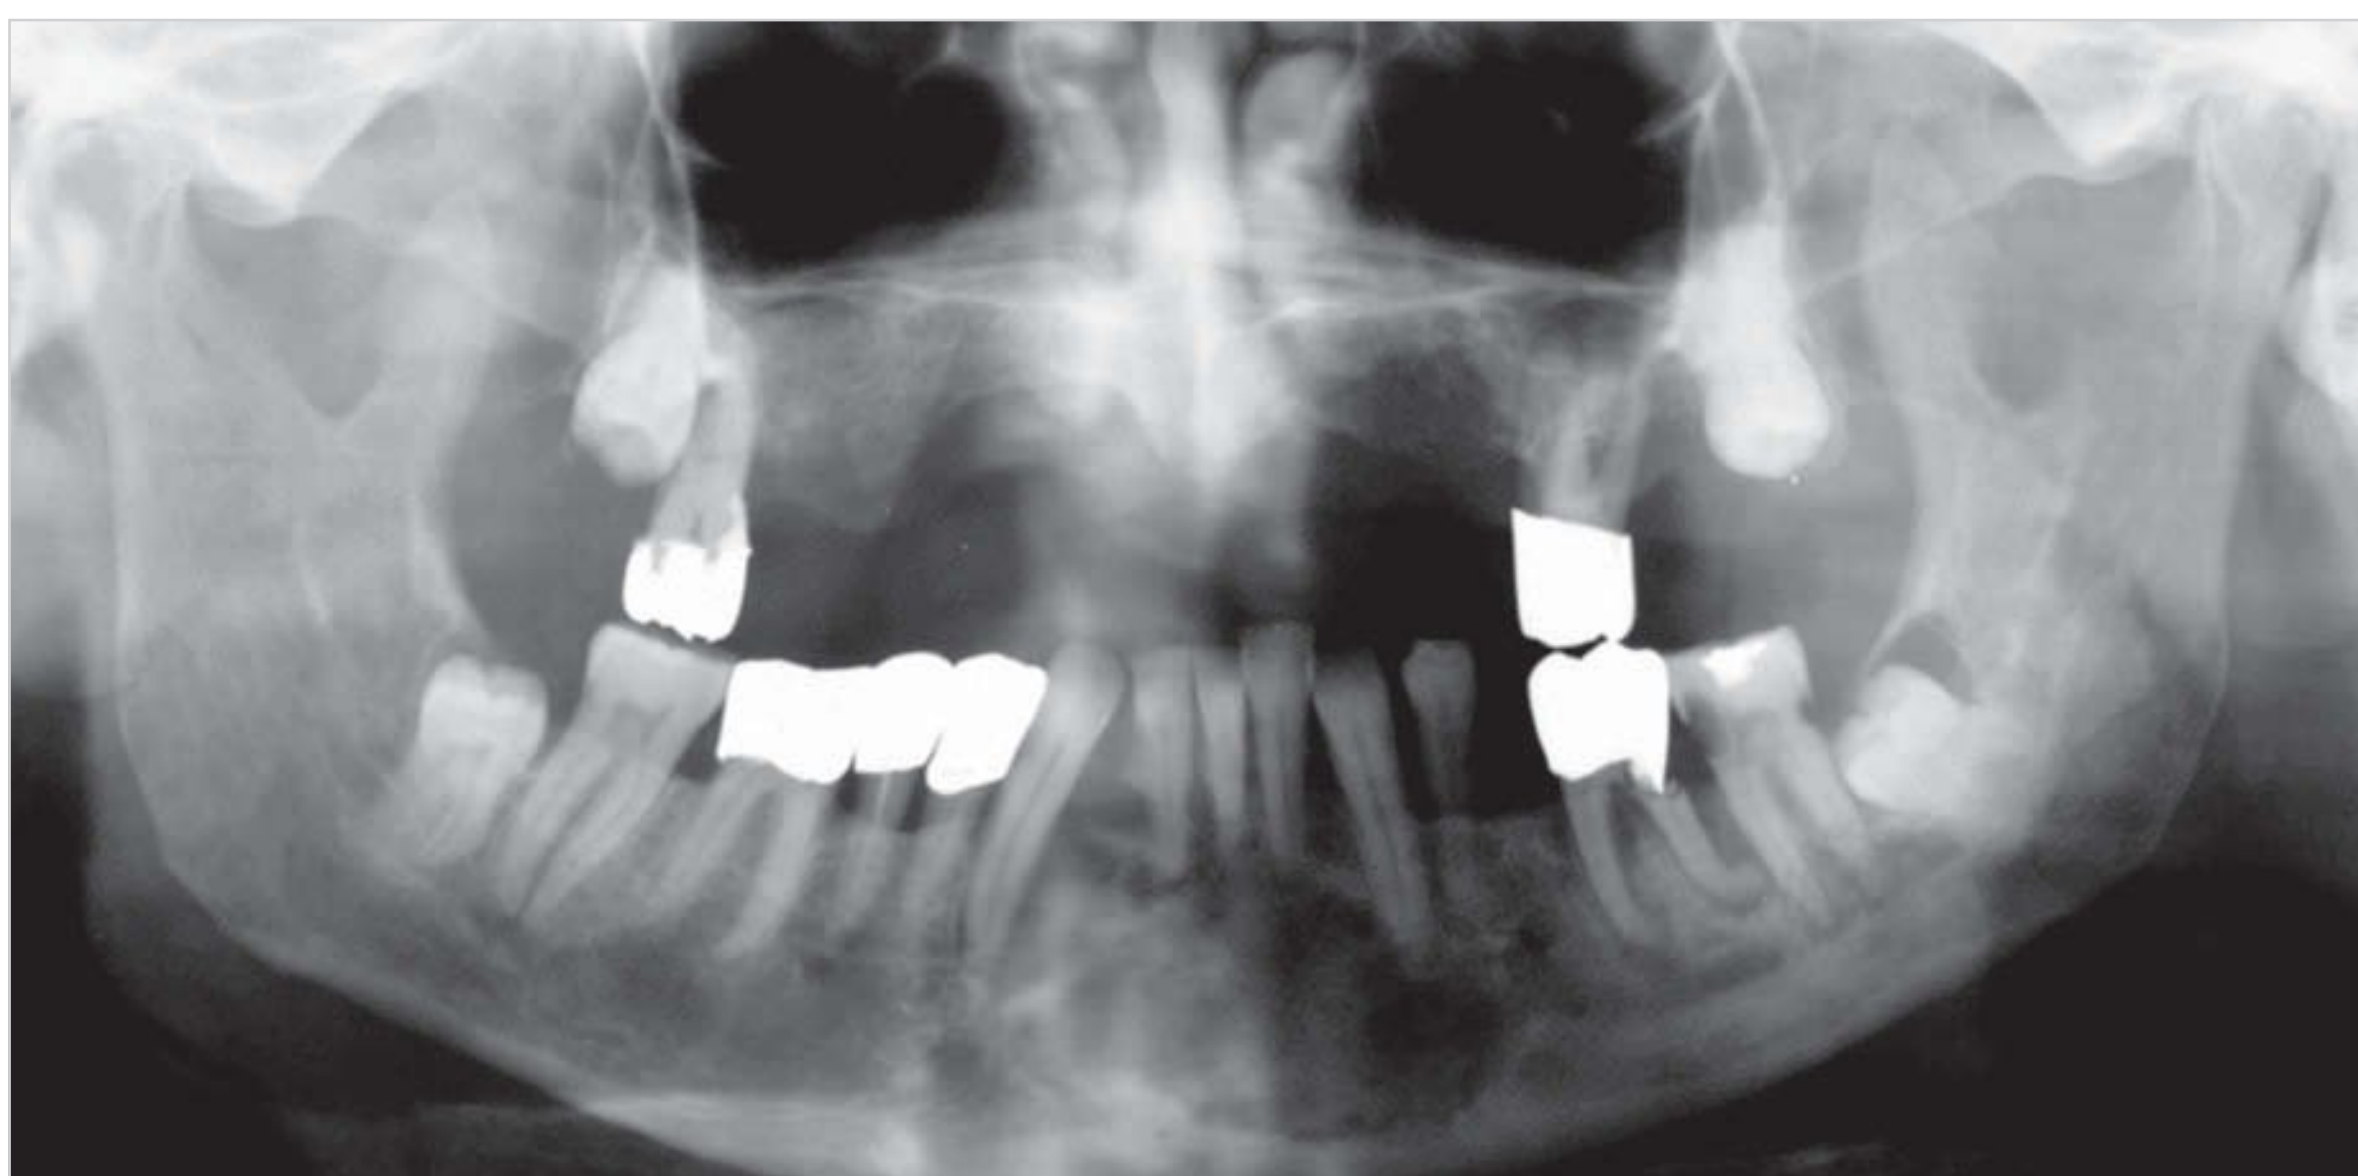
Central giant cell granuloma: note the discernible but not sharply demarcated round radiolucency in the anterior mandibular region, which appears oval as a result of distortion related to the radiographic technique.
